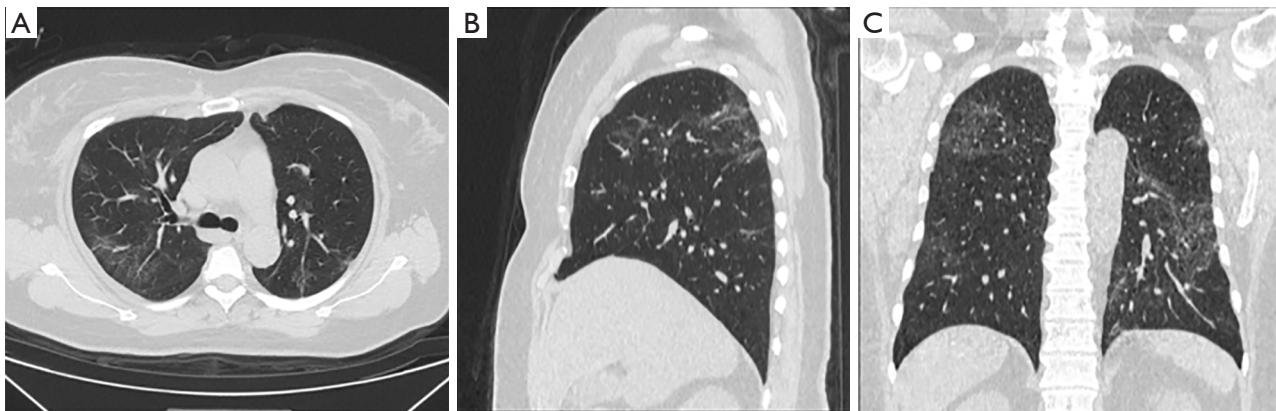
An early case of COVID-19, who presents multiple ground glass shadows and subtle mesh signs in the periphery of bilateral lungs on CT (pictures from the mobile cabin CT of Wuhan Optics Valley mobile cabin hospital).
